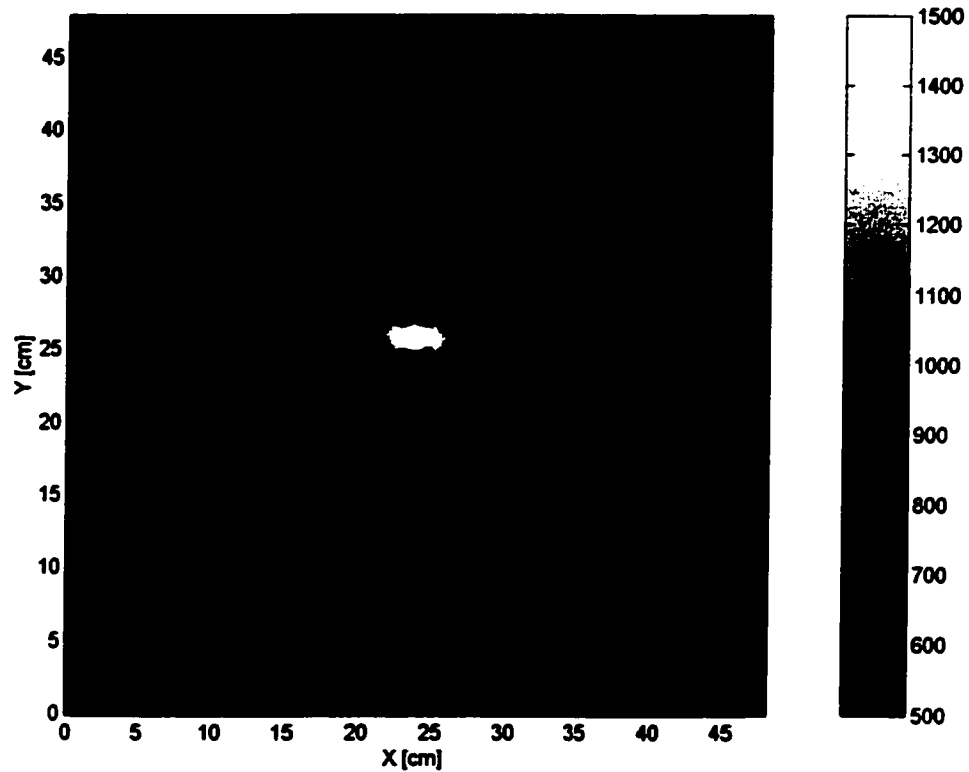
An example of CT image artifacts from the time-dependent signal. On the right is the window and leveling of the CT image.
